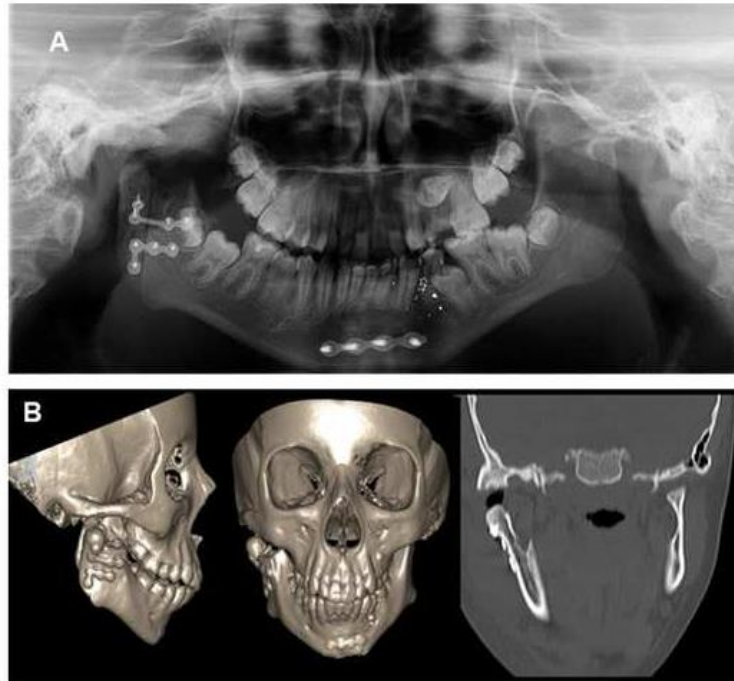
Panoramic radiography after five months of surgery (Fig. 6A). In CT scan it is possible to verify the absence of the ankylotic mass (Fig. 6B).
